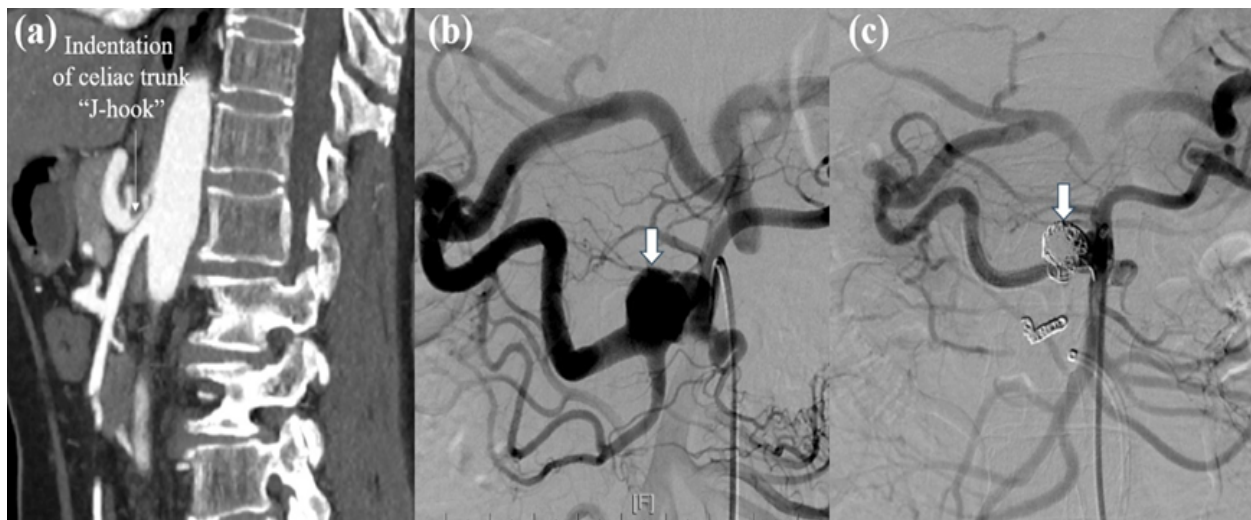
(a) Anterior indentation, the classic “j-hook” sign, of celiac artery on computerized tomography-angiogram (CTA), leading to the development of median arcuate ligament syndrome (MALS); (b) Presence of a 2.1 cm aneurysm (indicated by the white arrow) originating from the dilated inferior pancreaticoduodenal artery (IPDA), accompanied by retrograde contrast medium filling of the celiac branches through the dilated IPDA, resulted from the stenosis of celiac trunk; (c) Successful total obliteration (indicated by the white arrow) of the aneurysm using Nester® and Tornado® Embolization Coils, followed by a GORE® VIABAHN® Endoprosthesis stent across the aneurysm neck to seal it and maintain collateral flow patency to the hepatic arteries from the IPDA.
